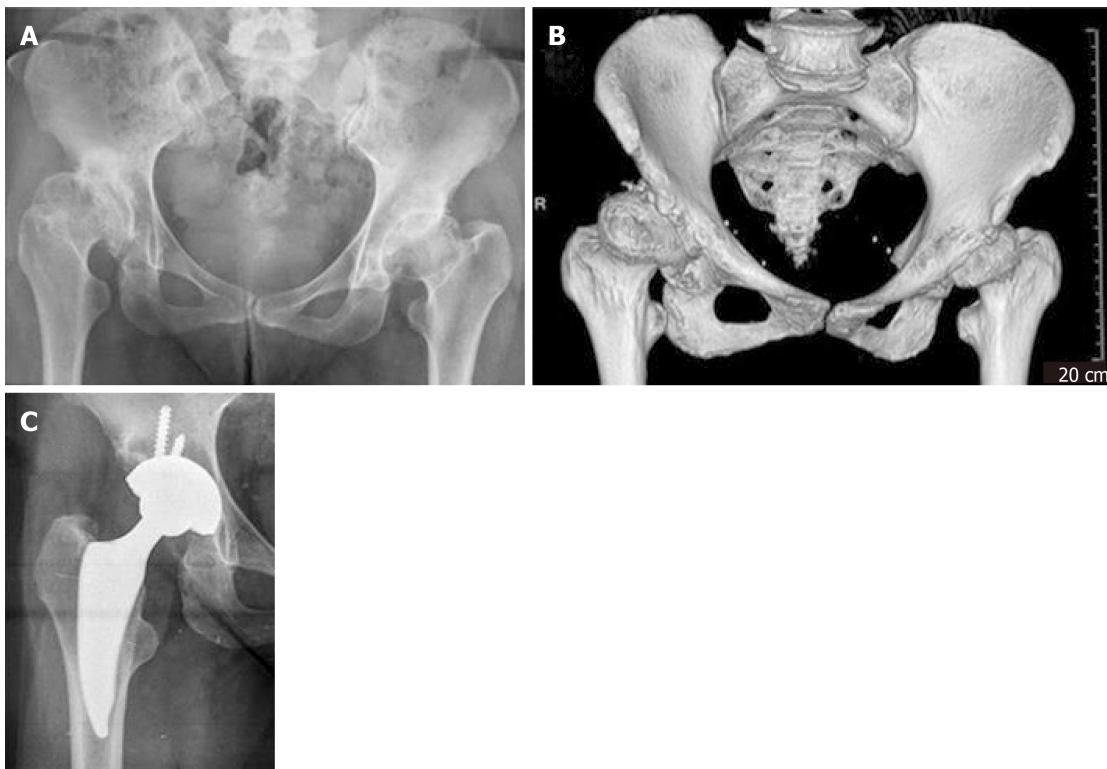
Hip dysplasia Hartophylakidis type II at the right side, and radiographs at 3 years postoperatively. A, B: Hip dysplasia Hartophylakidis type II at the right side; C: Radiographs at 3 years postoperatively.
